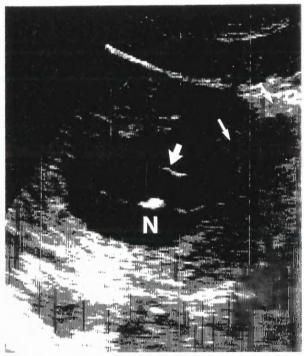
Ultrasound picture of 9 week singleton pregnancy showing the tip (N) of the needle (thin arrows) located centrally within the amniotic cavity having pierced the amniotic membrane (thick arrows), rather than within the extra-embryonic coelom.
